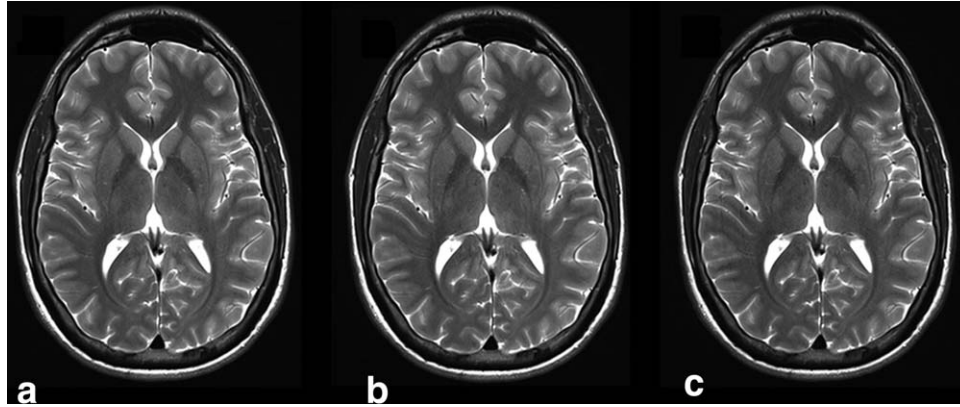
T2-weighted 2D TSE volunteer images using (A) the clinical routine implementation, (B) the identical protocol with optimized gradients, and (C) an optimized sequence with slight protocol adaptations. Images have identical windowing. The measured acoustic noise levels are (A) 88.8 dB(A), (B) 82.5 dB(A), and (C) 74.4 dB(A).
